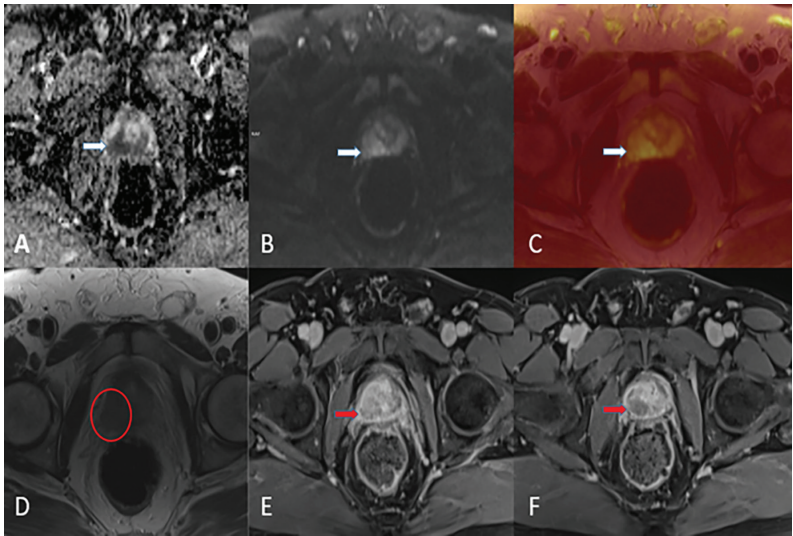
Shows mpMRI of the prostate in a 64-year-old male with elevated PSA, demonstrating a PI-RADS 4 lesion. On axial imaging, a focal lesion is seen in the right peripheral zone at the mid-gland level. The T2-weighted image A) demonstrates a moderately hypointense lesion without definite extracapsular extension, whereas the diffusion-weighted image B) shows marked hyperintensity of the lesion. The corresponding apparent diffusion coefficient map C) confirms restricted diffusion. A T2-weighted image with a red circle D) highlights the lesion's exact location. Dynamic contrast-enhanced imaging E) reveals early focal enhancement of the lesion compared with the surrounding parenchyma, and the color-coded perfusion map F) emphasizes the hypervascularity. The lesion was assigned a PI-RADS 4 score, and targeted MRI-ultrasound fusion biopsy confirmed clinically significant prostate adenocarcinoma (Gleason score 3+4, Grade Group 2).
